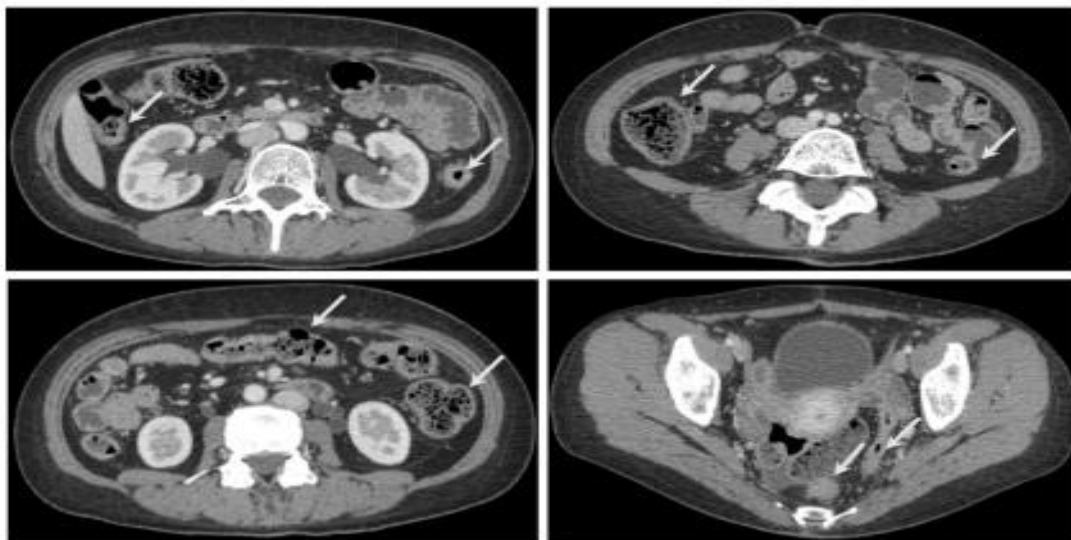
After one week of therapy, patients contrast-enhanced computed tomography scan revealing normal colon (white arrows)
